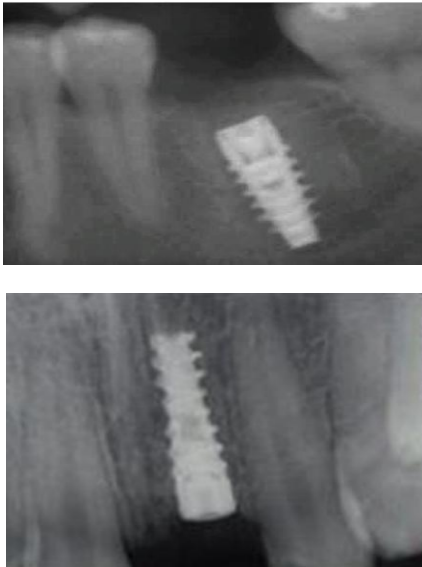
Post operative radiographs for confirming the angle of placement of implants
